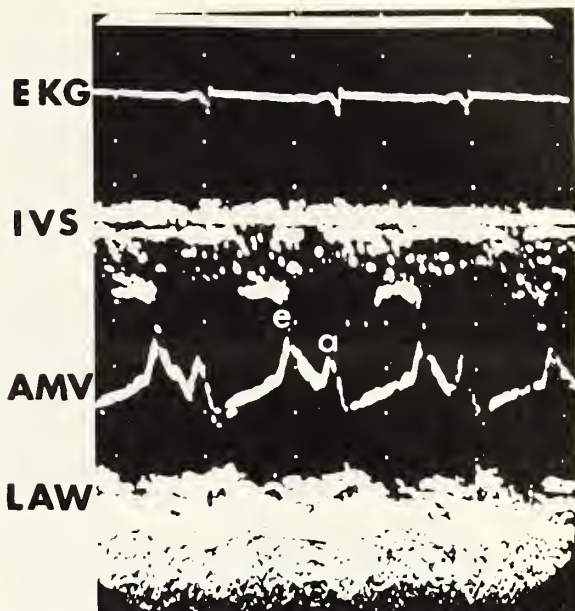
Echocardiogram of a normal mitral valve. Note the two peaks of anterior motion during systole labeled E and A.
